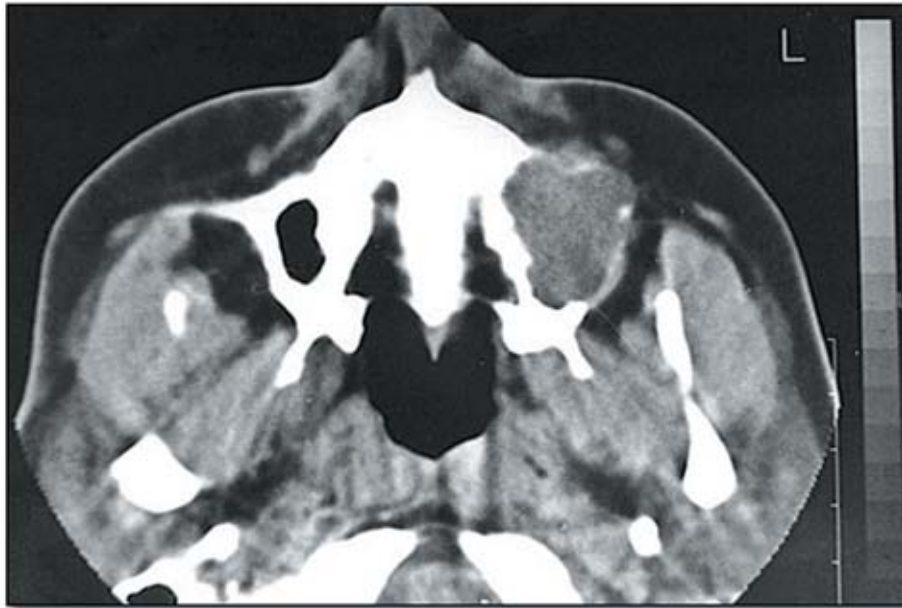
Bony destruction of the tumor on lower left antral walls on an axial CT image.
